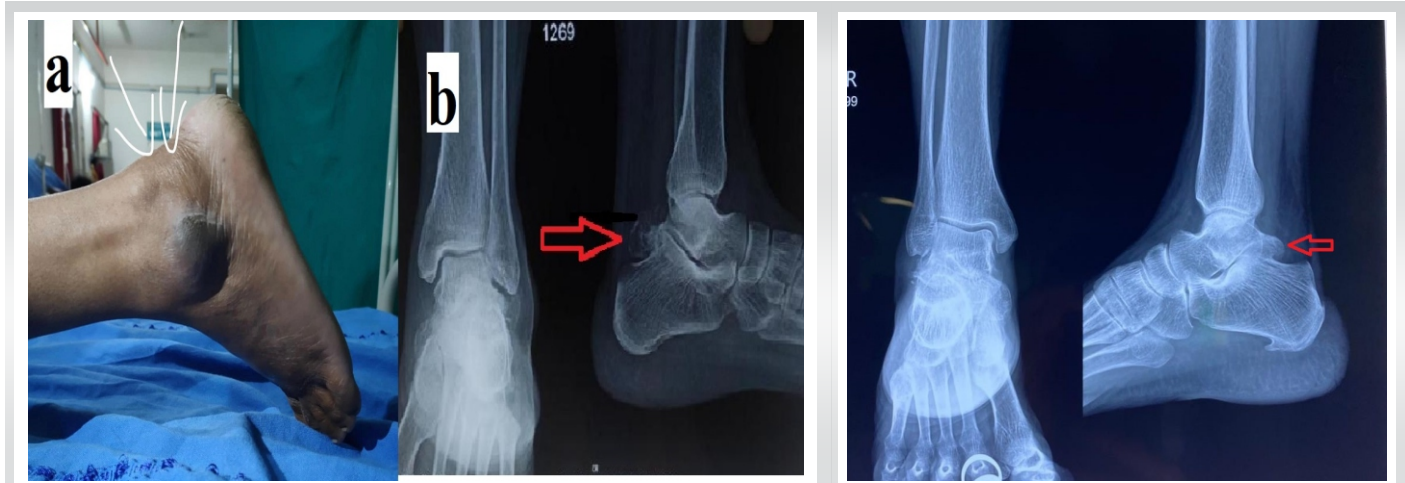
Clinical images showing swelling over the posterior aspect of the ankle due to large os trigonum osteophyte complex (white arrow) (a), and radiographs anteroposterior and lateral view showing large os trigonum osteophyte complex (red arrow) (b).
